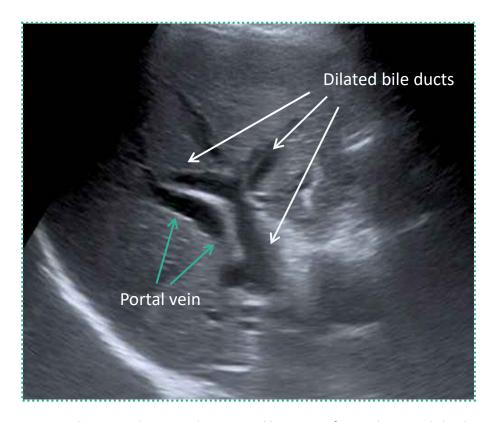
Ultrasound image depicting dilatation of intra-hepatic bile ducts.
